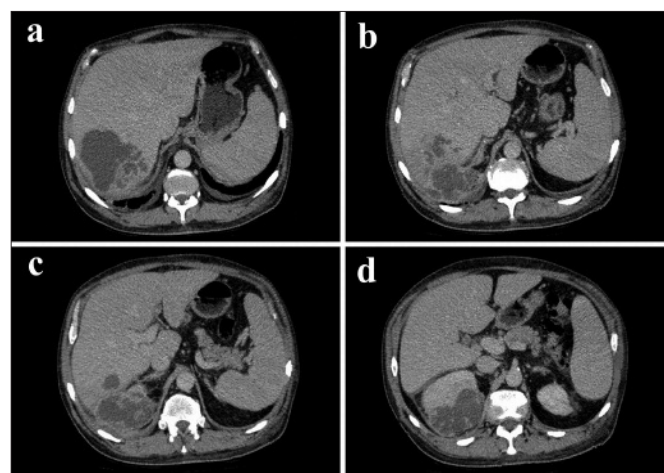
(a,b,c,d): Multidetector computed tomography imaging of liver and renal suppurative collections before (a,b) and after the treatment (c,d).
